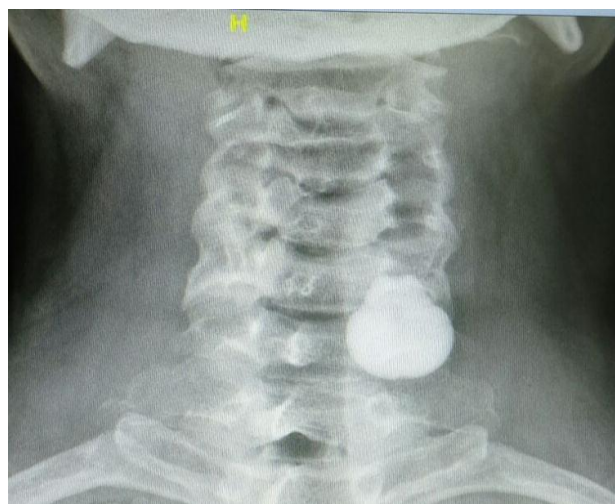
Plain x-ray soft tissue neck AP view showing pear shaped radiopaque foreign body in left pyriform fossa region.
